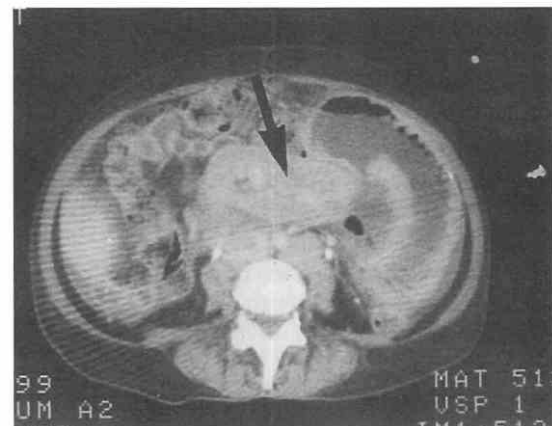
Lymphoma. CT scan shows a large soft tissue mass (*arrow*) in the root of the mesentery. The tumor extends to the wall of the small bowel, which is quite thick. Even when the bowel is distended, the mucosal markings can be seen.
